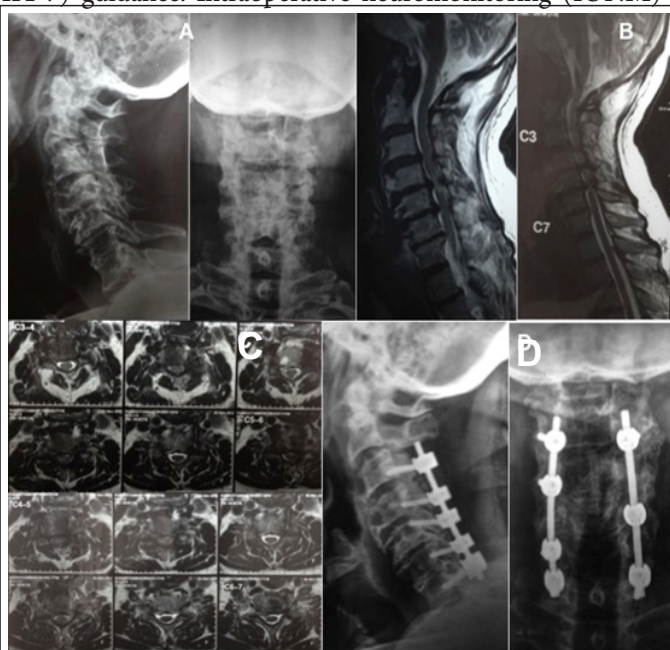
Male patient aged 79 years with cervical spondylotic myelopathy. (A) preoperative plain AP and lateral view x-rays (B) preoperative MRI had abnormal T2-weighted signal in the spinal cord at level of C4–C5 disc on sagittal image (C) preoperative MRI shows multilevel cervical stenosis from C3–C6 levels on axial images and (D) postoperative plain AP and lateral view x-rays view showing laminectomy and fixation.
